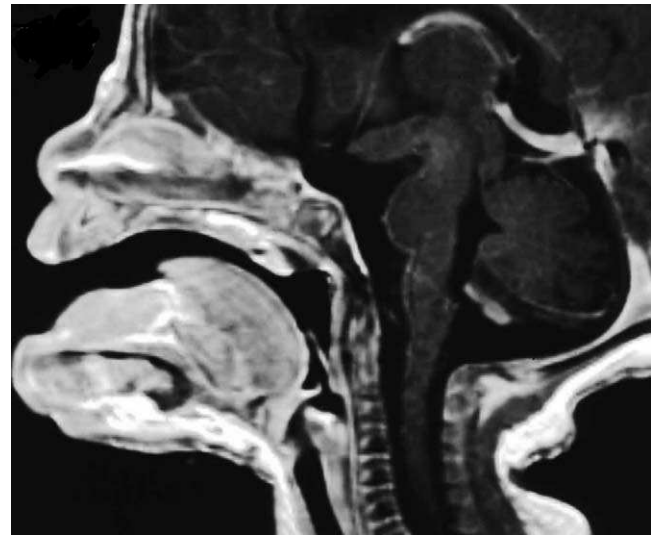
Sagittal MRI view showing the extent of the accessory mandible.
